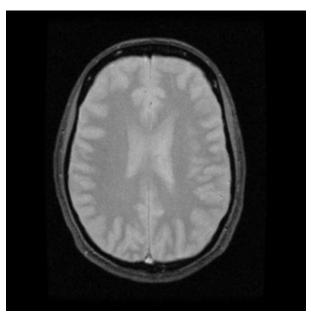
Top-down view of an MRI of the author's brain, intended to visually capture (and conquer) her chronic pain symptoms as neurological and curable.
